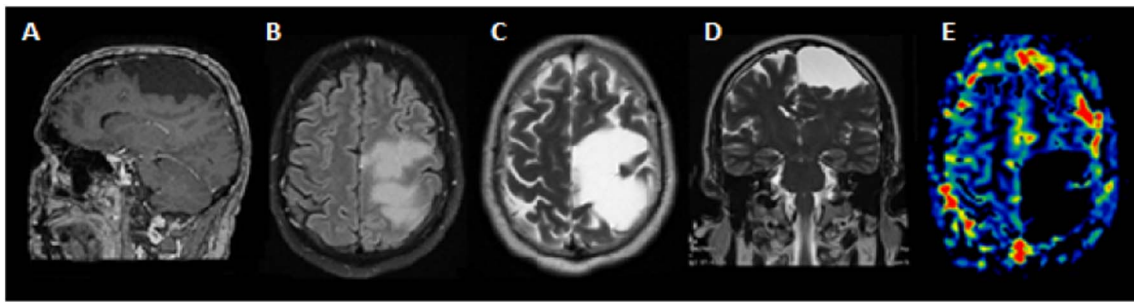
Preoperative sagittal T1-weighted (A), axial Flair (B), axial T2 (C), and coronal T2 (D) MR images demonstrating an extra-axial frontoparietal cyst with intensity similar with the cerebrospinal fluid (CSF). E: Perfusion technique showing a cold region in the cyst area.
